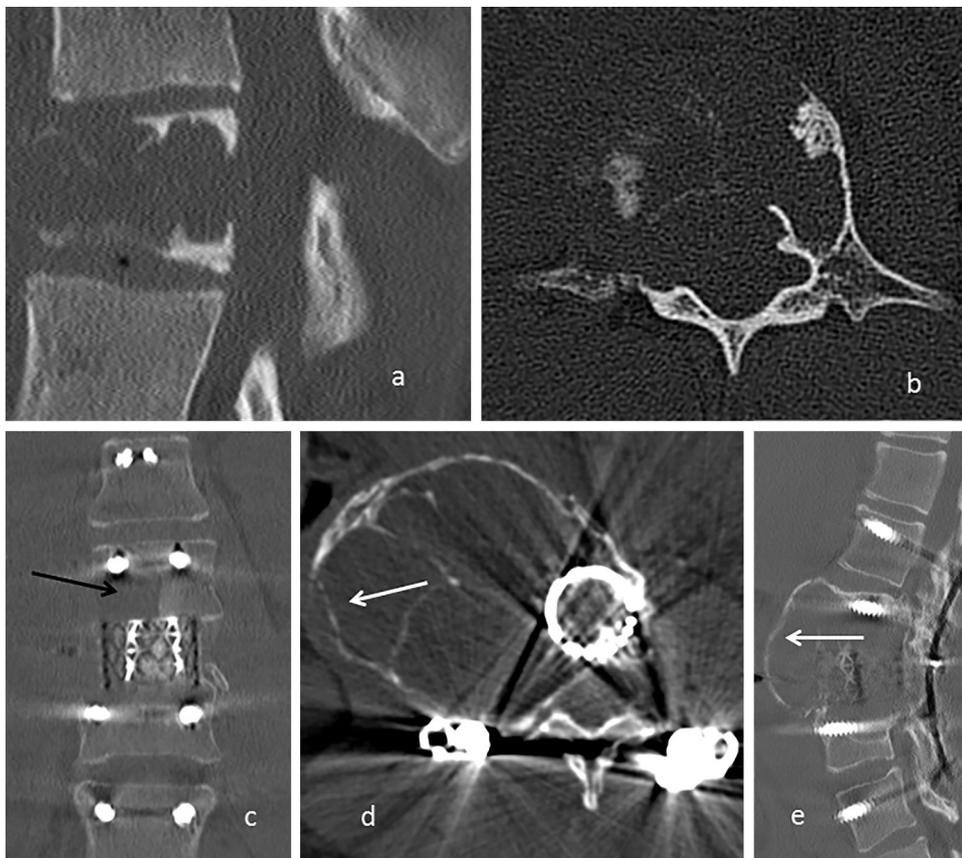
Patient #5 a and b: Computed tomography (CT), sagittal and axial views showing osteolysis with a pathological fracture of L3; c: CT, recurrence 6 months after surgery (black arrow); d and e: CT 6 months after denosumab initiation, cortical bone is visible peripherally and along the septa within the lesion (white arrows), while the size of the lesion is unchanged (RECIST).
